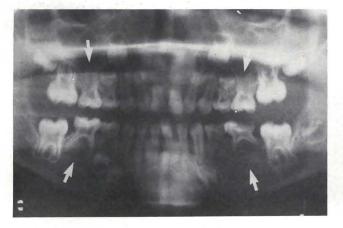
A radiograph of a 7.5-year-old female with hypodontia of the four second premolars. Additionally, note the absence of the right second mandibular molar.
